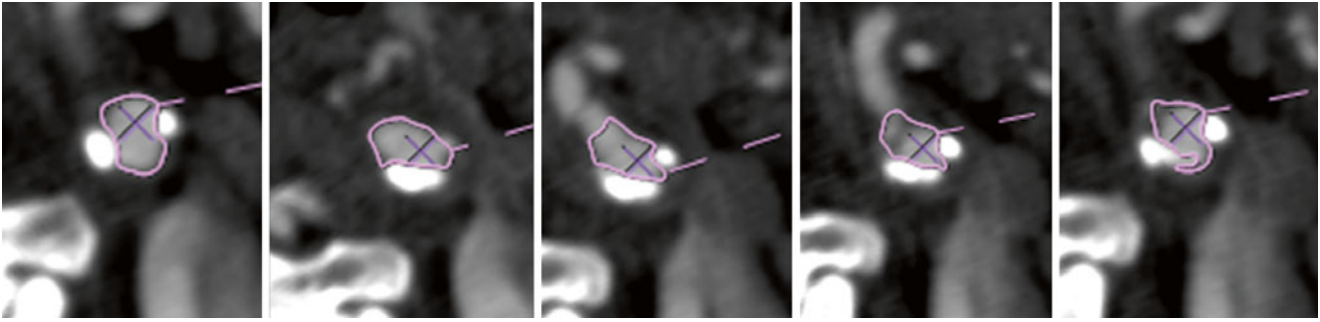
When using an automated 3D CTA analysis program, several misregistrations of the enhanced carotid artery lumen were noticed
